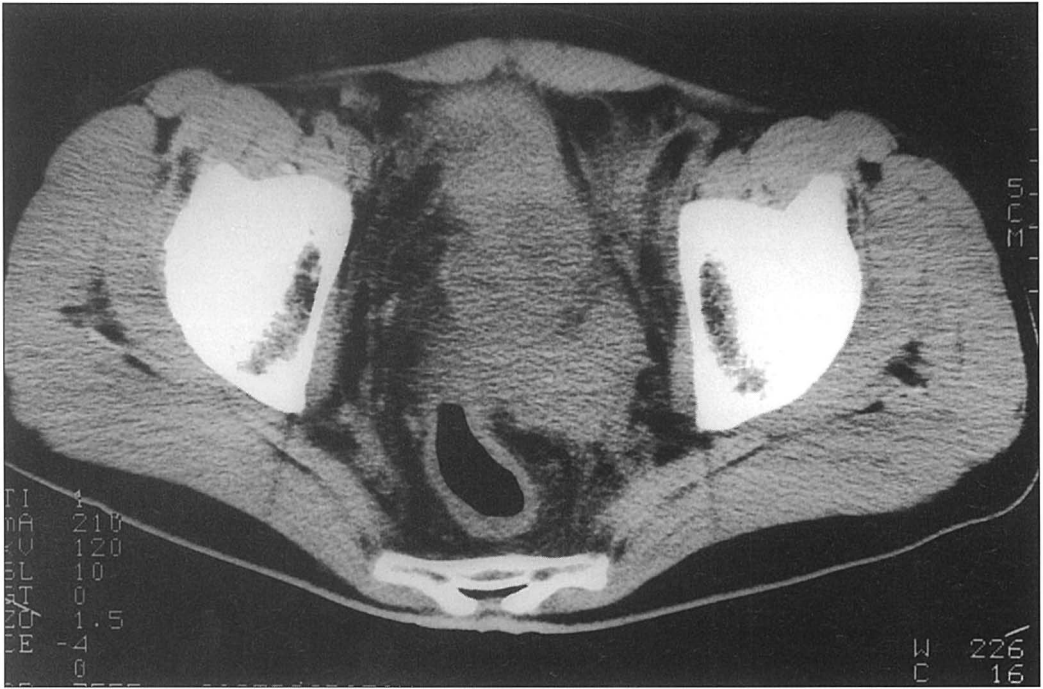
(a) CT visualization of tumor residuum in pelvis minor. (b) CT visualization of soft-tissue tumor in between the intestinal loops.
